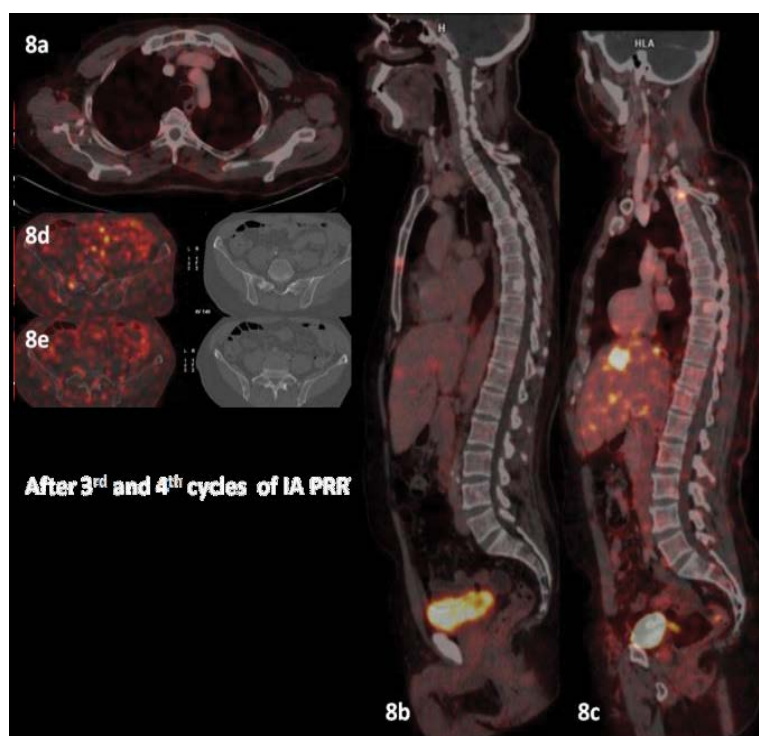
In patient 1, baseline PET CT showed both SSR avid and non-avid sclerotic skeletal metastases, few of the SSR avid bony lesions showing either decrease in the intensity of metabolic activity or resolution of tracer uptake suggestive of partial response. While few lesions showed resolution of tracer uptake after 2 cycles of IV PRRT with interval sclerotic changes, others showed stable uptake after the 4th cycle following an initial mild decrease after 2 cycles of IV PRRT or mild tracer reduction after 2 cycles of IA PRRT.
